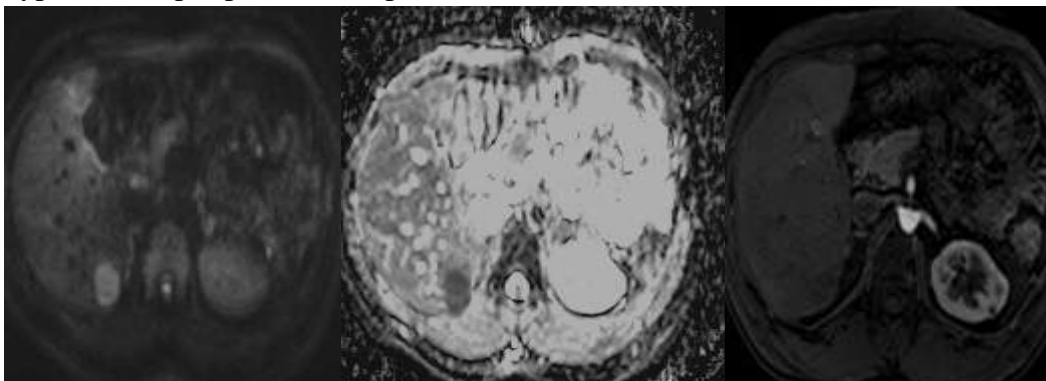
Lesion appear hyperintense in DWI with signal drop in ADC, showing diffusion restriction. Post contrast arterial phase lesion shows mild enhancement .
